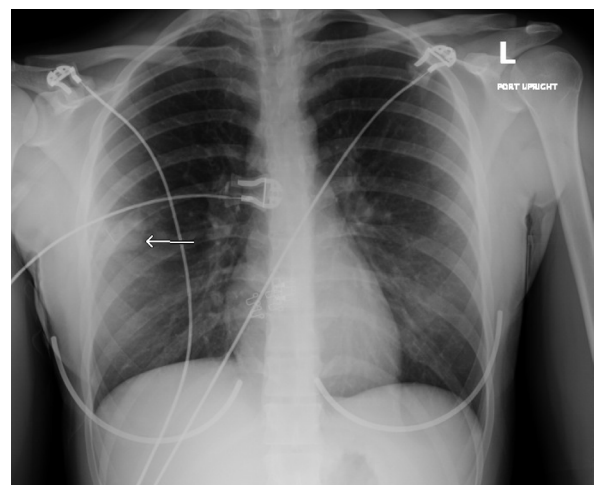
Admission AP chest X-ray showing right mid-lobe air space opacity.
